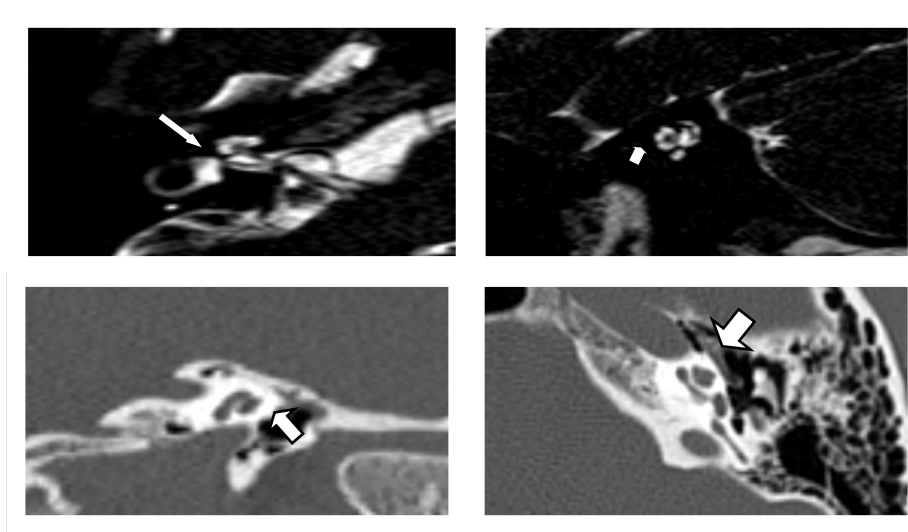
IP 2 in both CT and MRI
